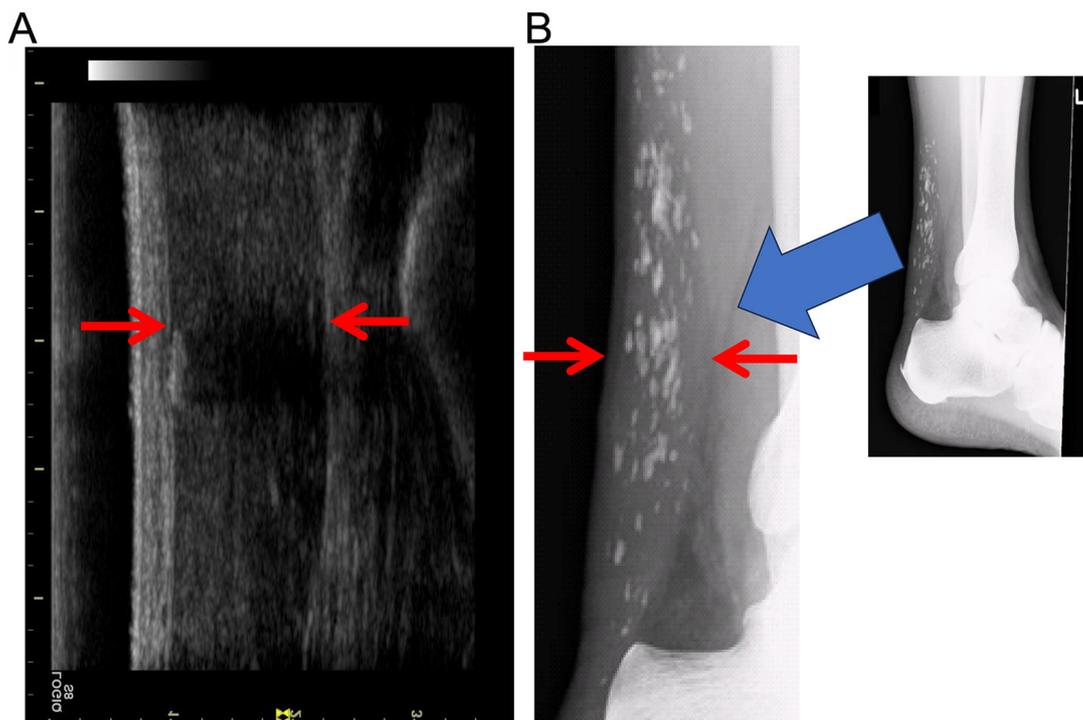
Achilles tendon image of a 77-year-old patient with Familial hypercholesterolemia by ultrasonography (A) and X-ray (B). The boundary of the Achilles tendon is clearly delineated by ultrasonography (A), but the boundary by X-ray is unclear (B).
